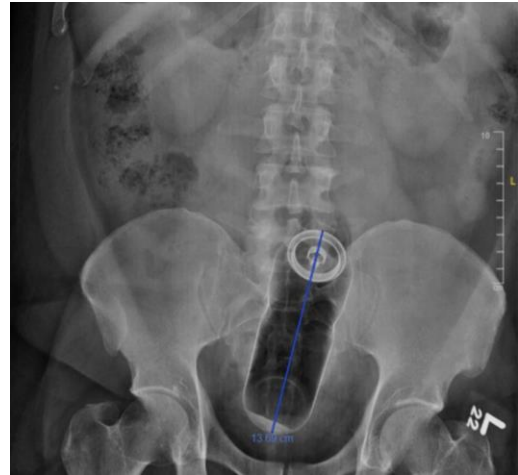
Abdominal radiograph showing a cylindrical radiopaque foreign body in the rectosigmoid junction.
